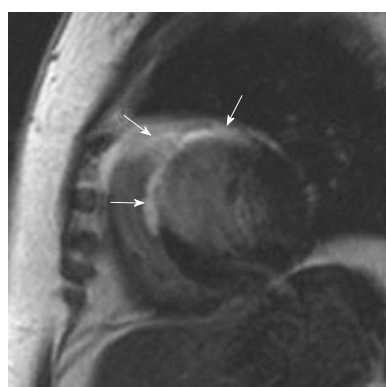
Cardiac sarcoidosis. A 54-year-old woman who presented with recurring palpitations and progressive shortness of breath for several months before suddenly collapsing. Cardiac magnetic resonance imaging demonstrates extensive scarring throughout the anterior and anteroseptal segments of the left ventricle (arrows). However, the involvement of the anterior segment of the right ventricle is unusual for ischemia and suggests another cause for the images. An endomyocardial biopsy revealed cardiac sarcoidosis. There was no previous history of lung or mediastinal sarcoid.
